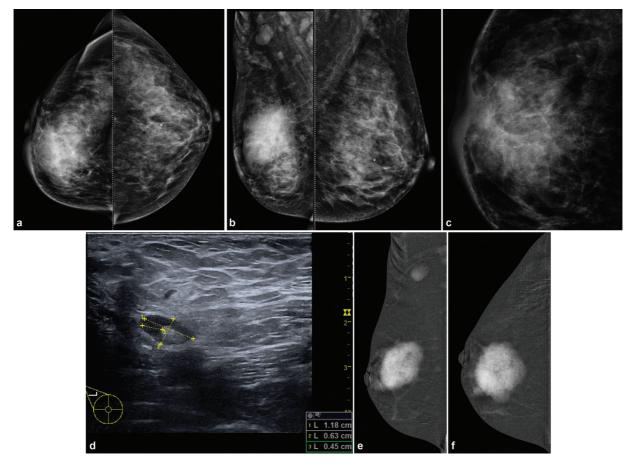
A 38-year-old female with increasing right breast lump since 15 months. Mammogram (A, B): An irregular high-density mass with indistinct margins is seen in predominantly upper inner quadrant also extending in the outer quadrant measuring approximately $4.4 \times 4.4 \times 5.5$ cm. Pleomorphic microcalcifications (C) are seen within the mass, better seen on magnification view. Diffuse trabecular thickening with nipple areolar complex thickening and retraction is seen. Few suspicious right axillary nodes are seen, largest measuring 1.2×0.7 cm with 4.5-mm cortical thickness (D). In view of dense breast parenchyma, further evaluation with CEM was performed to rule out any other lesion in breast, CEM (E, F) is suggestive of large unifocal lesion. This is the case of locally advanced breast cancer (stage IIIA), further metastatic work-up was performed. On CT scan, (G, H) heterogeneously enhancing mass is seen involving right breast with involvement of overlying skin. Enlarged right axillary, right internal mammary, and right supraclavicular lymph nodes are seen. (CEM, contrast-enhanced mammogram.)
